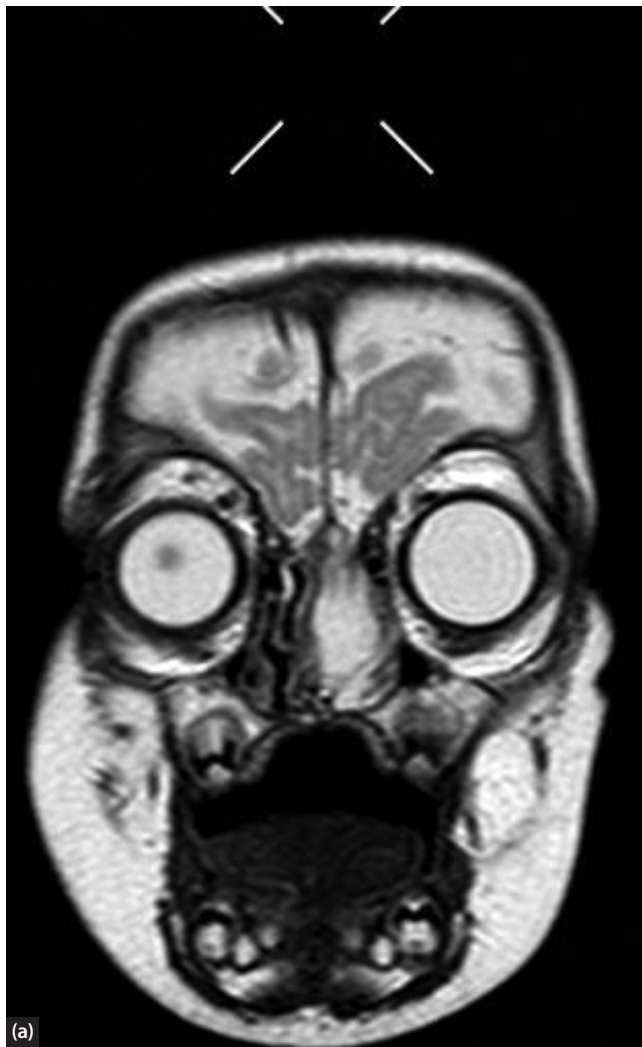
(a) MRI T2-weighted image of frontoethmoidal encephalocoele. Note the hypertelorism. (b) MRI-STIR TSE showing frontoethmoidal encephalocoele.
